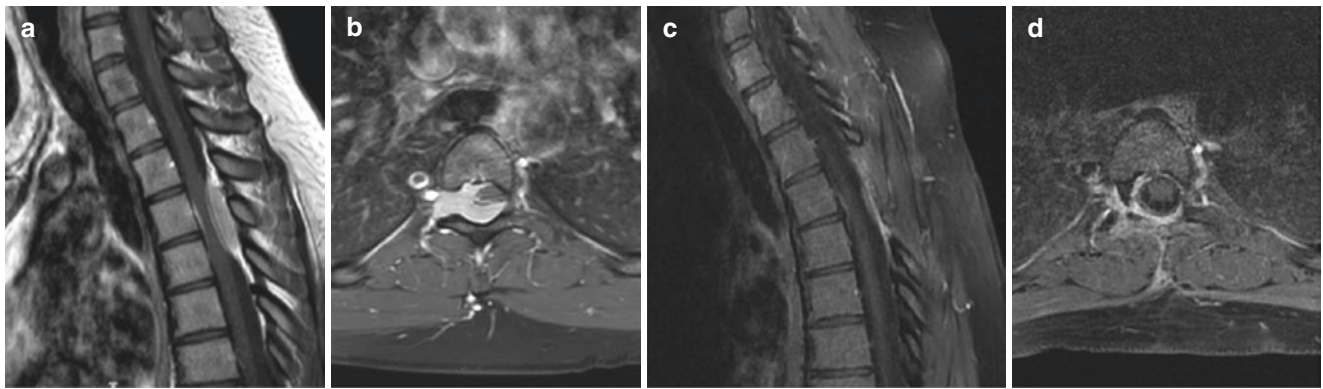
MRI imaging: (a) preoperative sagittal MRI with contrast showing the contrast-enhancing dorsal spinal epidural lesion; (b) preoperative axial MRI documenting the sleeve-like epidural lesion; (c, d)
